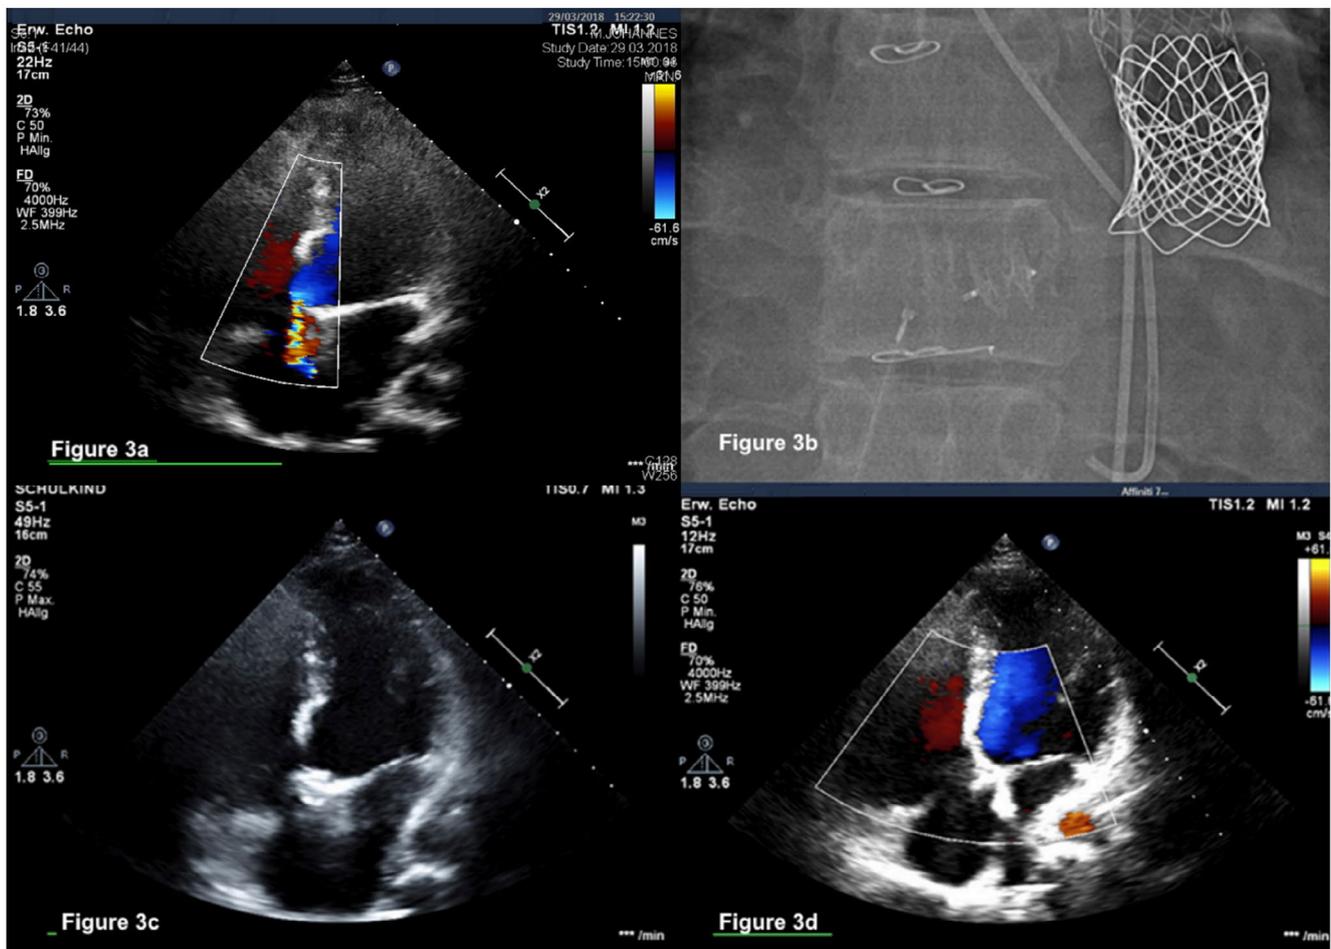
Demonstrates an iatrogenic Gerbode defect in a 20-year-old patient (Patient 15) after Rastelli surgery for repair of a double outlet right ventricle with transposition of the great arteries and subpulmonary obstruction. A, The echocardiographic 4-chamber view; the colored jet under the tricuspid valve to the right atrium assumes high endocarditis risk. B, The ADO II occluder within the left ventricular to right atrial shunt defect as well as the previously placed Melody 22 mm valve for reconstruction of the previously reobstructed right ventricular outflow tract. C, The ADO-II occluder positioned within the previous postsurgical Gerbode-like defect by echocardiography. D, Effective closure of the previous left ventricular to right atrial shunt by color Doppler
